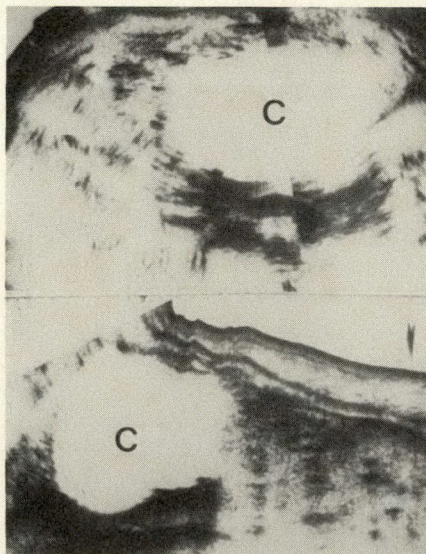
Ultrasonogram showing pseudocyst (c) of pancreas: upper portion, transverse section; lower portion, sagittal section.
